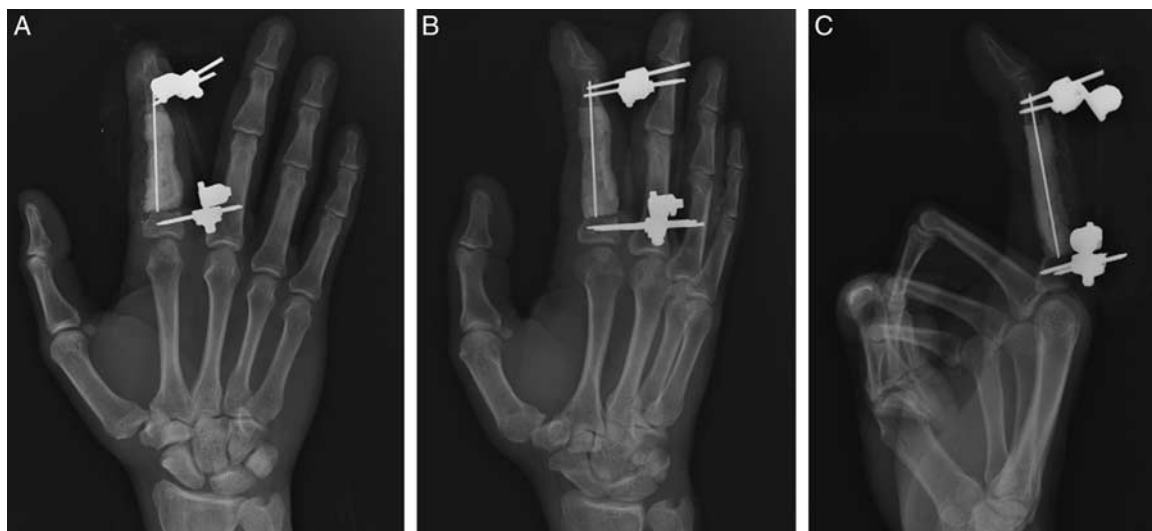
A–C, X-ray of hand on April 30, 2018.
